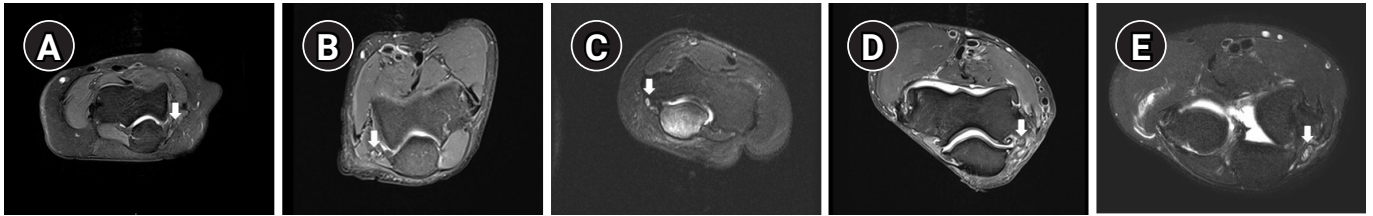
The severity based on the magnetic resonance imaging (MRI) findings using a 5-point score was evaluated based on the signal alteration and/or swelling on the fat-suppressed T2 weighted axial sequences. The images around the elbow were divided into 3 sections from 2 to 6 cm above the medial epicondyle (section 1), from 2 cm below the medial epicondyle to 2 cm above the medial epicondyle (section 2), and from 2 to 6 cm below the medial epicondyle (section 3). Fig. 1 shows representative images for the evaluation of ulnar neuropathy in section 2, and the ulnar nerve is indicated with white arrows. (A) Axial MRI on the right side depicts score 0 with a normal finding of the ulnar nerve. (B) Axial T2 fat-suppressed image shows a mild signal change (score 1). (C) Axial T2 fat-suppressed image on the left side presents a severe signal change (score 2). (D) MRI of the right elbow shows a signal change with mild swelling (score 3). (E) Axial MR on the right side depicts severe swelling with a severe signal change (score 4).
